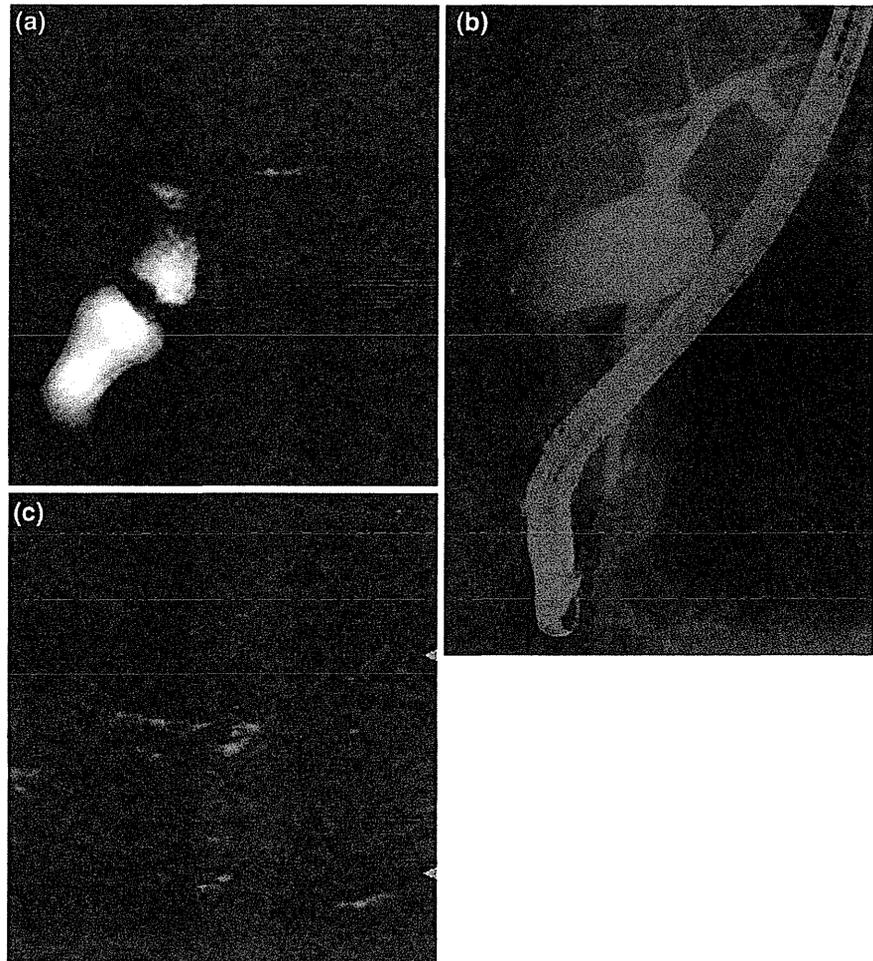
Pancreaticobiliary maljunction without biliary dilatation was suspected by magnetic resonance cholangiopancreatography (MRCP) (a) and confirmed on endoscopic retrograde cholangiopancreatography (ERCP) (b). Ultrasonography in this patient showed gallbladder wall thickening (c)
